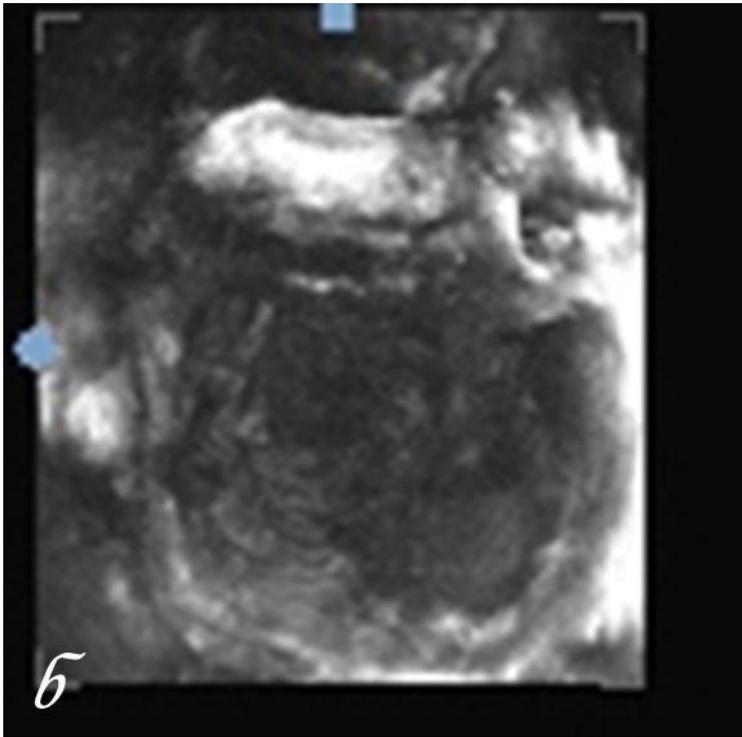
Transabdominal ultrasound, 3D mode — a) three mutually perpendicular planes form a three-dimensional array; b) a three-dimensional reconstruction — cystic formation with a thick, lumpy inner loop.
